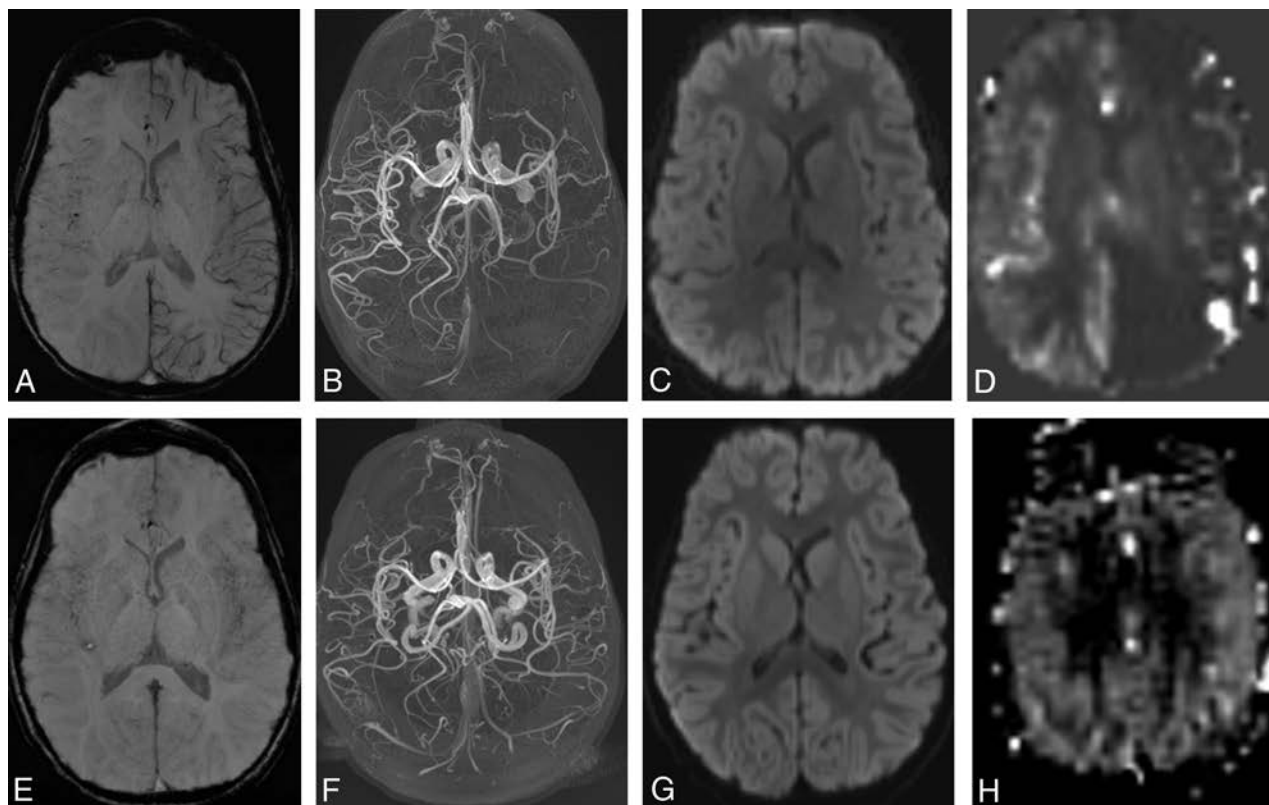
A 5-year-old boy presenting with right-sided weakness. Symptoms were improving at the time of the initial MR imaging performed 3 hours after presentation (A–D). A, Susceptibility-weighted imaging shows increased prominence of the cortical veins throughout the left cerebral hemisphere, indicating increased deoxyhemoglobin on the left. B, Collapsed maximum intensity projection from time-of-flight MR angiography shows reduced flow-related enhancement in the left anterior, middle, and posterior cerebral arteries. C, The average trace of the diffusion tensor image shows no abnormality of diffusion. D, Pulsed arterial spin-labeled perfusion-weighted imaging relative CBF map shows a marked decrease in perfusion throughout the left cerebral hemisphere. Follow-up imaging at 4 days after presentation (E–H). E, SWI shows resolution of venous asymmetry. F, MRA shows normal flow-related enhancement in the left anterior, middle, and posterior cerebral arteries. G, Findings of the average trace image continue to be negative. H, Pulsed arterial spin-labeled relative CBF map shows resolution of perfusion asymmetry.
